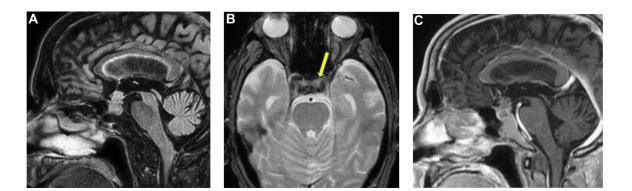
(A-C). The FLAIR sequence (A) highlights the presence of an expansive lesion affecting the pituitary gland with predominantly suprasellar development, poor differentiation between the adenohypophysis and the neurohypophysis, arriving in close contiguity with the optic chiasm. The FFE T2 sequence (T2*) highlights some spots, within the pituitary lesion (yellow arrow), hypointense, compatible with contextual hemorrhagic microfoci (B). T1 post contrast sequence (C), sagittal plane, shows a non-homogeneous enhancement of the pituitary expansive lesion.
